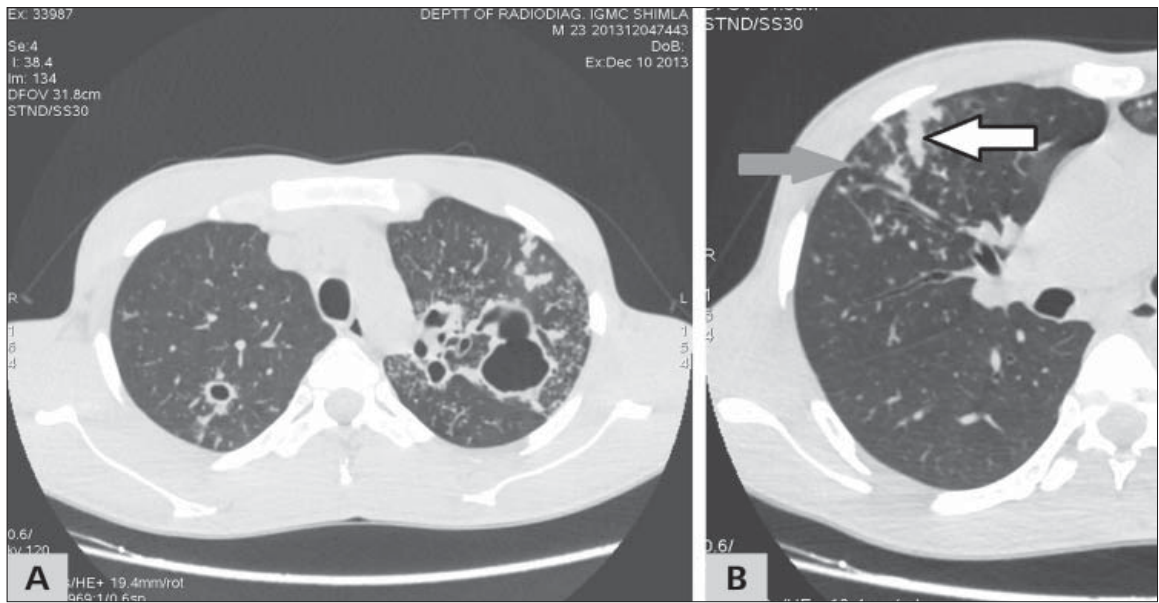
(A) Axial HRCT images of a twenty three year old male showing presence of cavitory lesions along with centrilobular nodules and consolidation in lobular pattern in the surrounding lung parenchyma in b/l upper lobes. (B) Magnified view of the same patient showing the centrilobular nodules, tree-in-bud appearance (dark arrow) and consolidation in lobular pattern (white arrow). This patient was given Rank 1 and proved to be tubercular on BAL examination.
